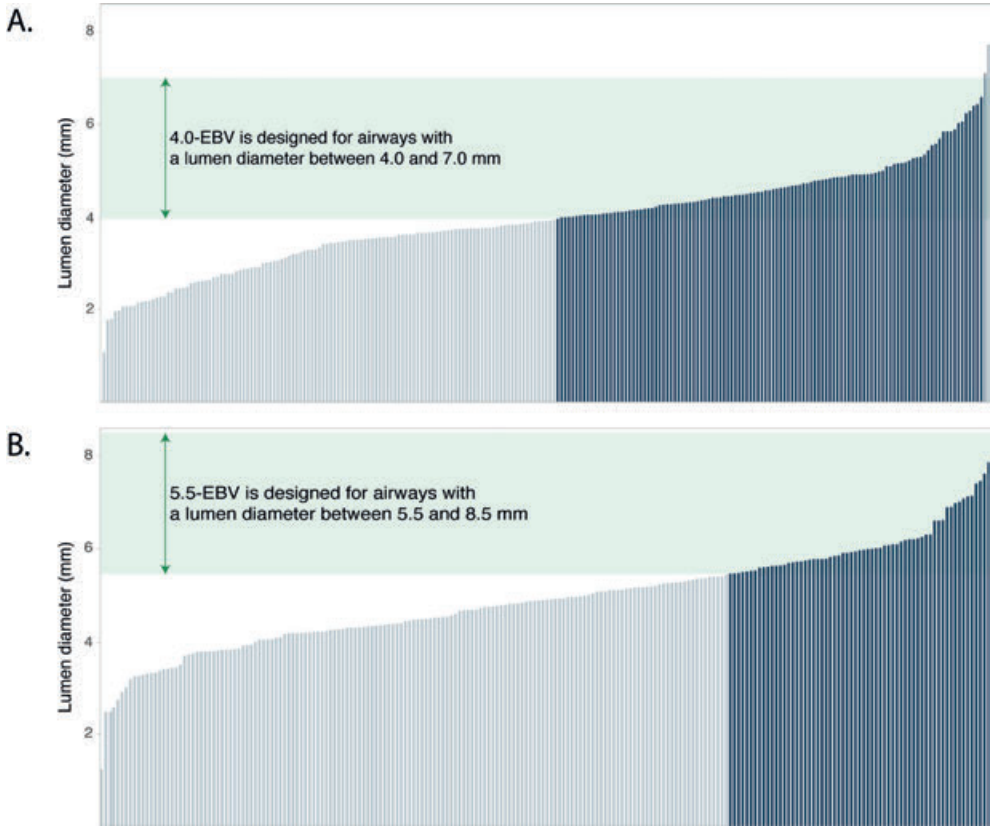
Waterfall plots displaying the CT-derived lumen diameter of the airway in which the endobronchial valve (EBV) was implanted A) 4.0-EBV B) 5.5-EBV. The green area indicates the airway lumen diameter range for which the valves are designed. The dark blue bars indicate the valves that have the appropriate size based on the CT-derived airway lumen diameter.
